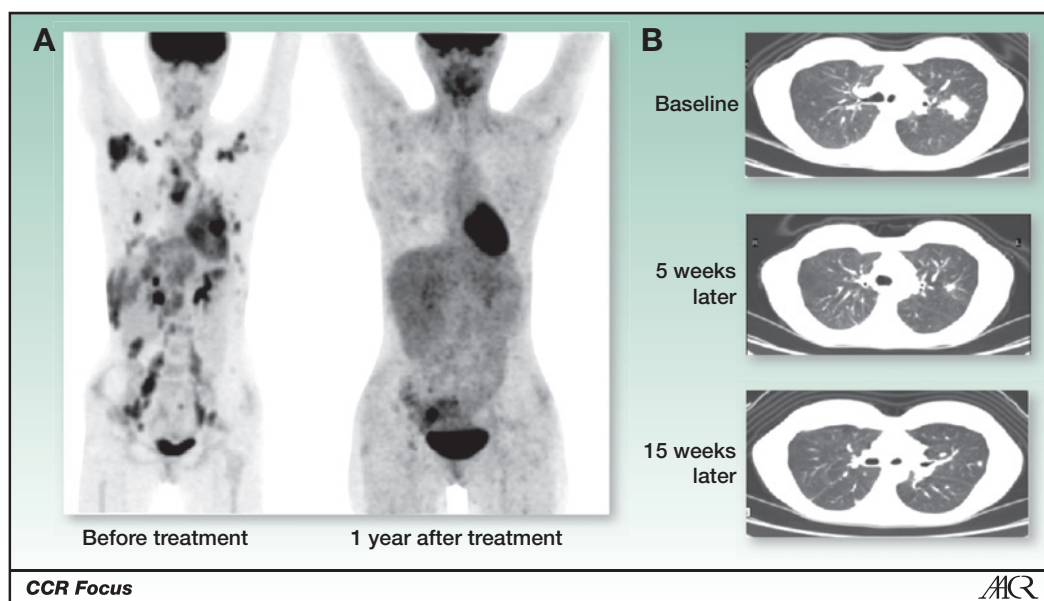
Response observed in a patient with Hodgkin's lymphoma after treatment with SIP(L19) labeled with ^{131}I . A, fluorodeoxyglucose PET analysis of the patient at presentation [courtesy of Prof. G. Mariani and Dr. P. Erba; adapted from Sauer et al. (50)] and 1 year after treatment with the radioimmunotherapeutic drug (at higher sensitivity). B, computed tomography analysis of a pulmonary lesion responding to treatment.
